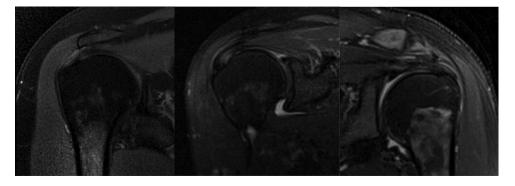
Tendinopathy grading on coronal magnetic resonance imaging (MRI). Left two images are of the right shoulder and right-most image is of the left shoulder. From left to right: mild indicates a focal area of increased signal, moderate indicates a more diffuse area of increased signal though still localized, and severe indicates diffuse signal change throughout the majority of the tendon.
